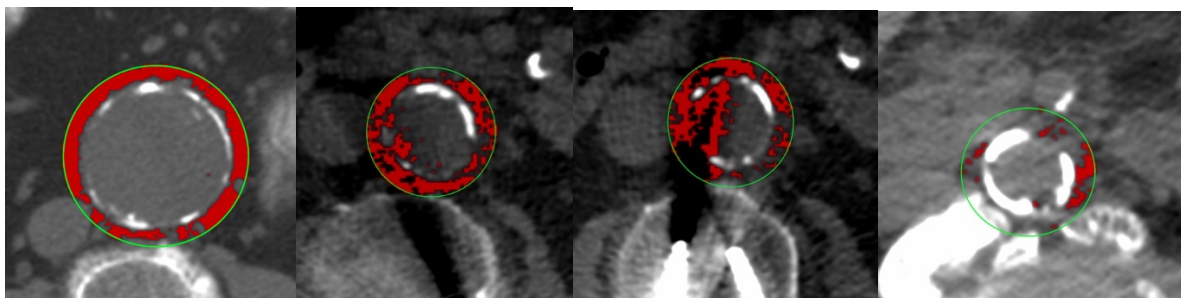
Presence of intraluminal pixels with values -45 to -195 HU in native CT scans. Usually, only solitary pixels in few axial CT images are seen (left image). Such pixels can be seen in the vicinity of metal/high density foreign objects, for instance near spinal osteosynthesis materials (middle two images). Alternatively, they can arise near very high-density calcium deposits in the aorta or vertebral column (right image).
